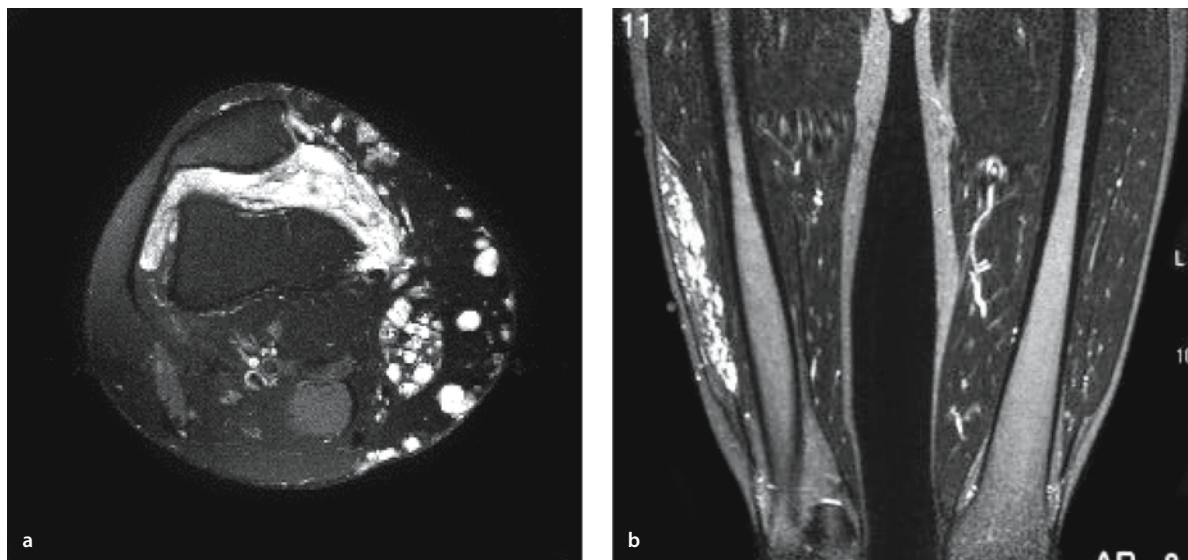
a, b. Venous hemangiomas: a axial T2-weighted image with fat saturation shows the involvement of multiple compartments of the knee region by the lesion. There are hyperintense nodular and serpentine areas in the subcutis, the semimembranous muscle and within the joint, in the anterior fat pad. High signal intensity is caused by slow flowing blood in dilated venous channels; b coronal inversion recovery T2-weighted image in another patient shows pooled blood within saccular dilated blood vessels. There is extension along the long axis of the involved leg
